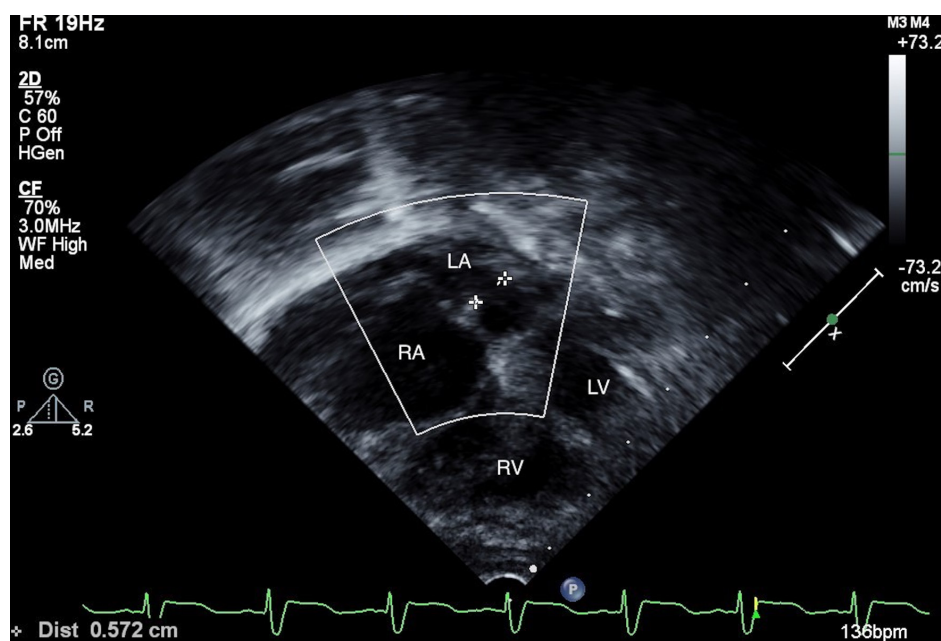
Transthoracic echocardiography demonstrating unroofed coronary sinus between (+) markers measuring 5.7 mm. LA, left atrium; RA, right atrium; LV, left ventricle; RV, right ventricle.
